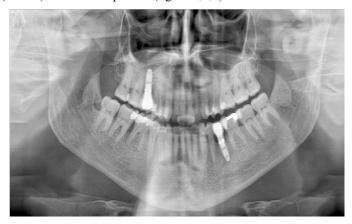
Initial panoramic x-ray
